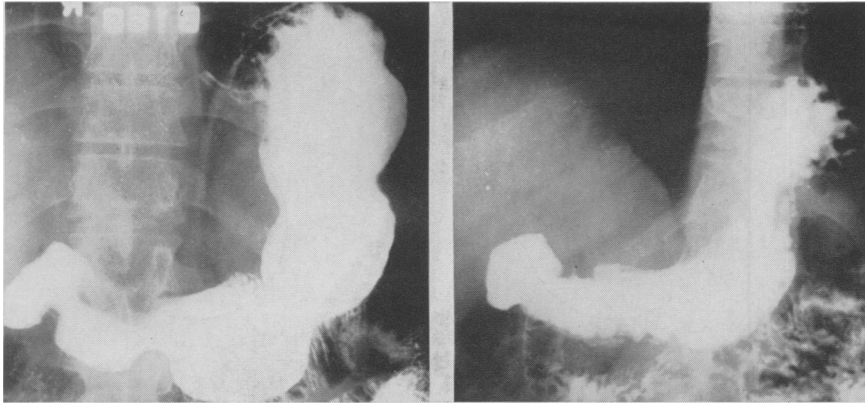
(Left). Gastroduodenal x-ray of C. R. W. (Case 2) taken January 22, 1953 before portacaval shunt. Esophageal varices are seen, but there is no gastric or duodenal ulceration.
